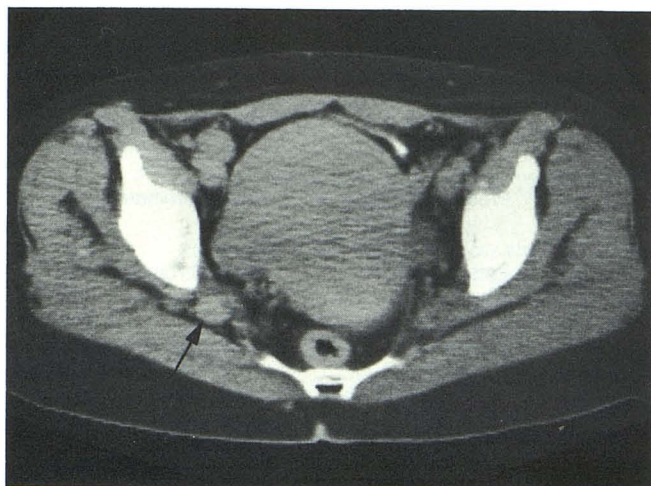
Case 3: neurofibromatosis and right-sided leg pain. CT demonstrates marked enlargement of right sciatic nerve (arrow).
